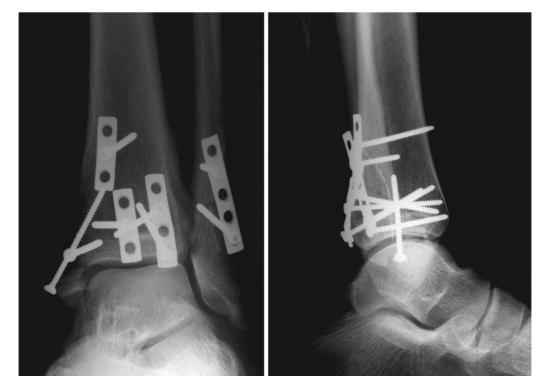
Anteroposterior and lateral radiographs of the ankle of patient no. 10 after open reduction and internal fixation. Congruency of the ankle joint was restored. Since the lateral edge of the posteromedial fragment was thin, an antiglide plate rather than a single screw was used to prevent the edge from fracturing. Since the tip of the anterior colliculus of the medial malleolus was fractured as well (see Figure 5,A, left image), it was fixed with an additional screw.
